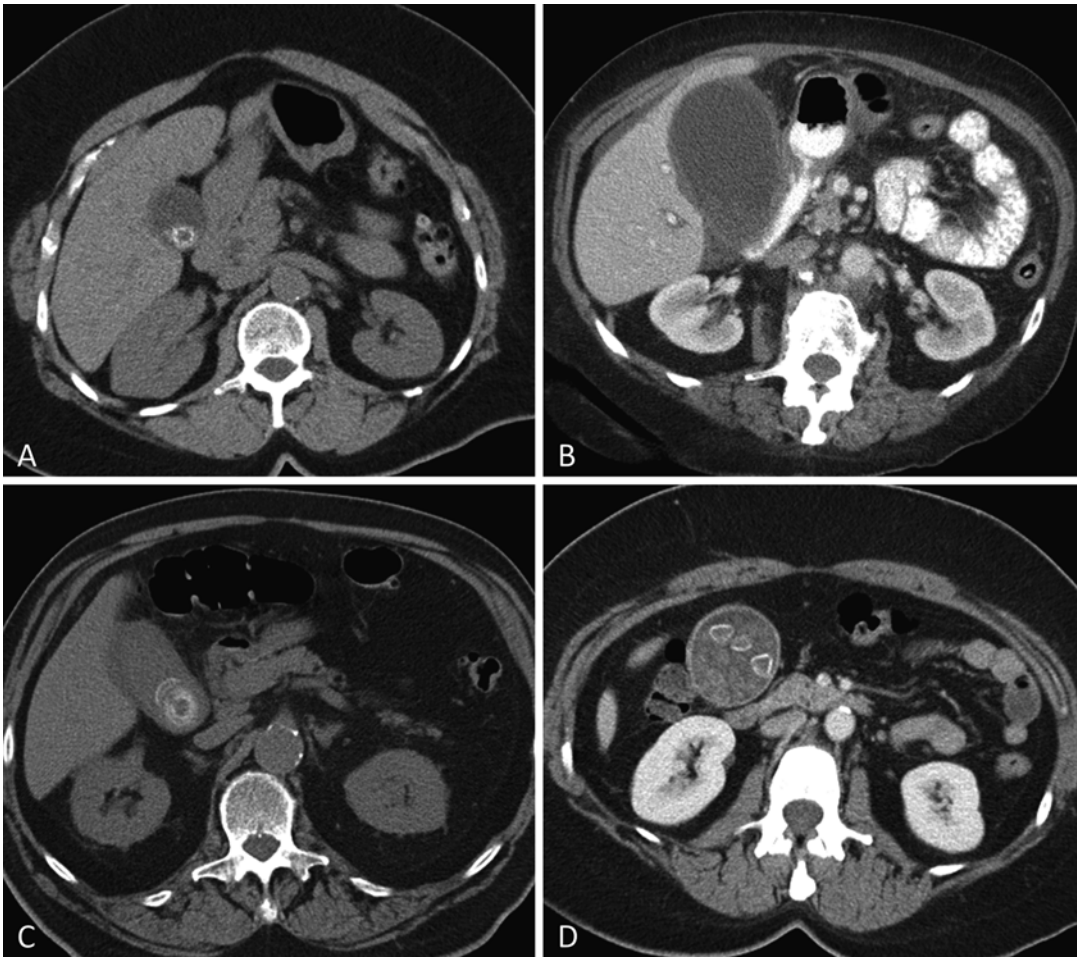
Axial images from CT scans of patients presenting with right upper quadrant pain. (a) Cholelithiasis. (b) Thickened gallbladder wall and pericholecystic edema.
